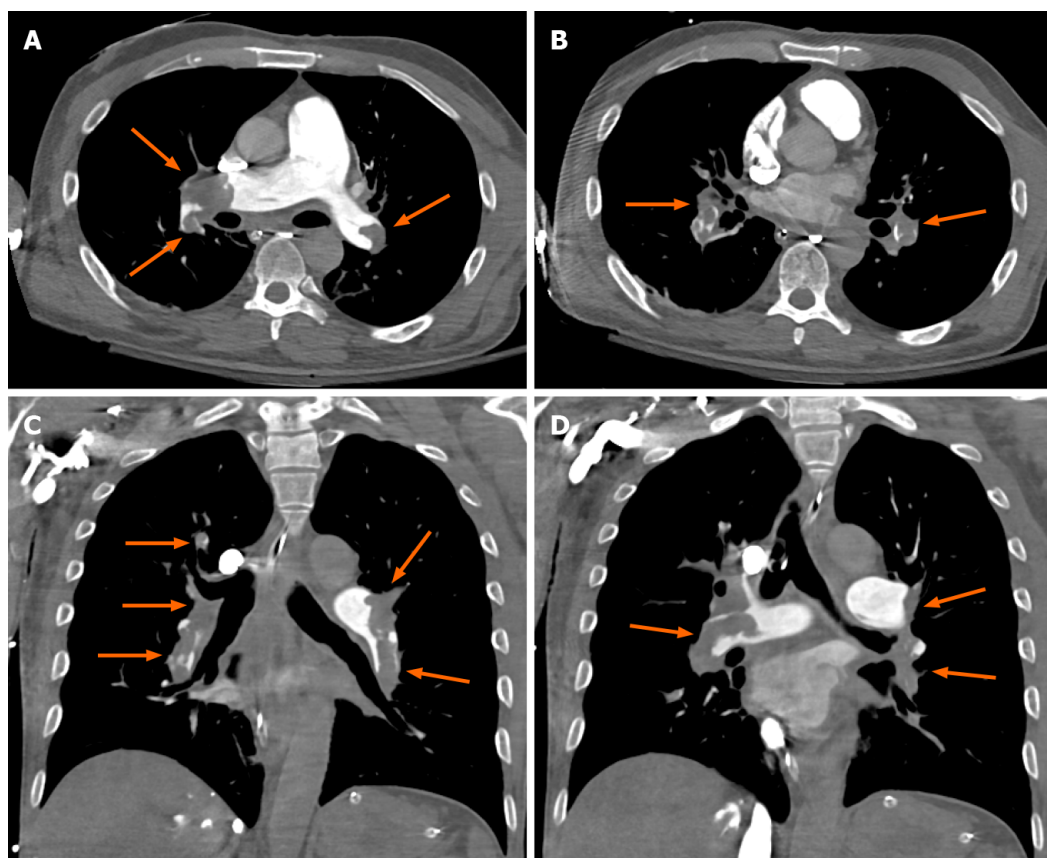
Computed tomography angiography images. A and B: Chest axial views; C and D: Chest coronal views. Computed tomography angiography chest axial and coronal views soft tissue window shows large hypodense filling defects in distal right and left main pulmonary arteries and all segmental pulmonary branches in both lungs (orange arrows) in a 58-year male patient with shortness of breath. Findings are compatible with bilateral extensive pulmonary embolisms.
